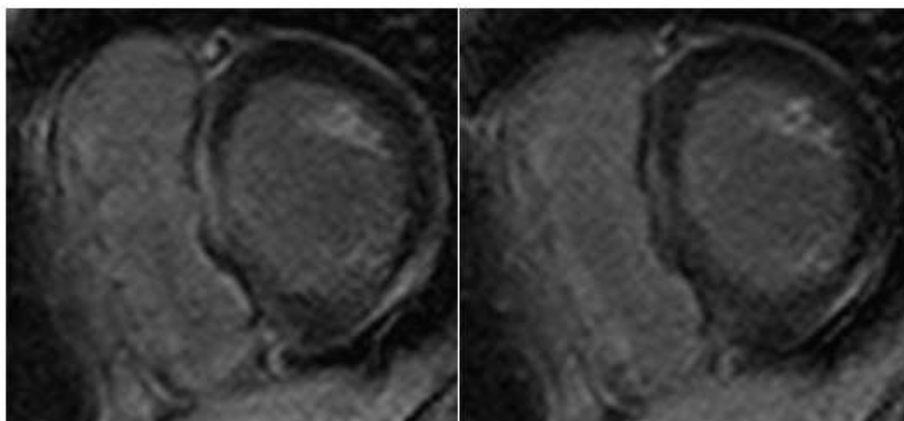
MRI showed diffuse thinning and irregularity in the interventricular septum at the basal and mid level suggestive of scar tissue (infarct)
